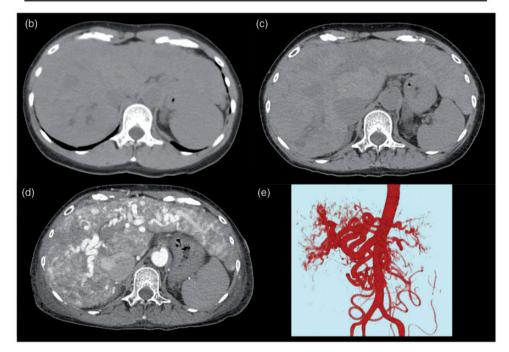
Haemodynamic data pre- and post-liver transplantation and arteriovenous malformations in the liver. A significant improvement in haemodynamic parameters was observed after liver transplantation compared to pre-transplant values (a). Compared with one year previously (b), low-density areas in the liver had enlarged on computed tomography scan indicating worsening of arteriovenous malformations (c). Contrast-enhanced computed tomography and angiography shows major shunt caused by arteriovenous malformations in the liver (d and e). PH: pulmonary hypertension; PCWP: pulmonary capillary wedge pressure; PAP: pulmonary arterial pressure; RAP: right atrial pressure; O₂: oxygen; SVC: superior vena cava; IVC: inferior vena cava; Qp: pulmonary blood flow; Qs: systemic blood flow.
